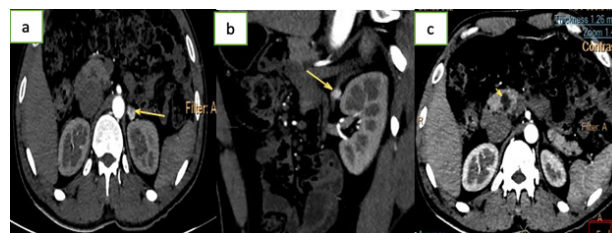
Post contrast axial and sagittal CT scan of abdomen (a,b) showing hypervascular lesion (yellow arrow) in left suprarenal region in left para-aortic region of abdomen. Axial CT abdomen (b) showing multiple cysts in pancreas; one of the cysts in pancreatic head showing multiple septations.
